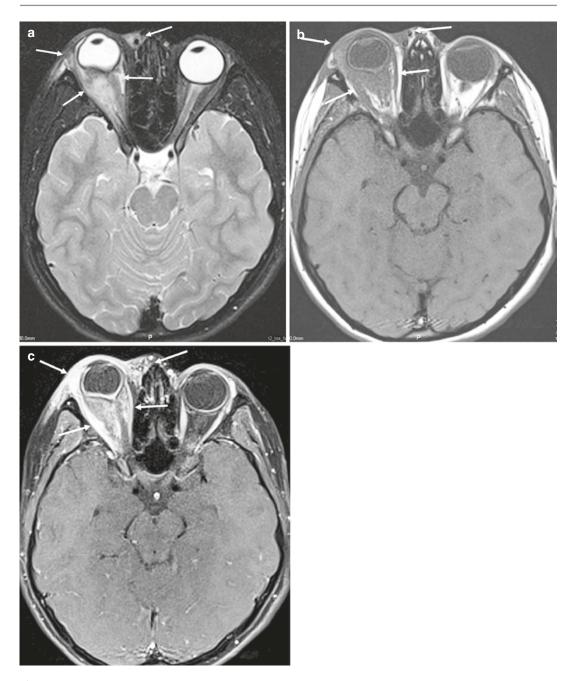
(a–c) *Inflammatory myofibroblastic tumor* in a 12-year-old girl who presented with swelling of the eyelid. (a) Axial fat-saturated T2-weighted MR image shows hyperintense infiltrative lesion (*arrows*) involving the right orbit. (b) Axial precontrast T1-weighted MR image demonstrates that the lesion (*arrows*) is isointense in signal intensity relative to muscle. (c) Fat-saturated postcontrast T1-weighted MR image shows heterogeneous enhancement of the infiltrative lesion with retrobulbar fat infiltration, involving the optic nerve, rectus muscles, tendons, and lacrimal gland (*arrows*) (Reprinted with permission from Oguz et al. [120])
